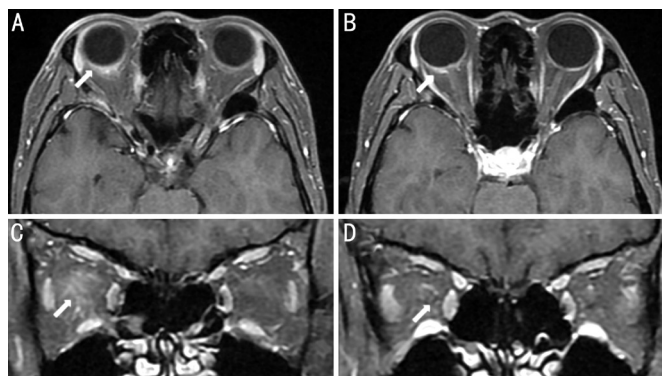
Magnetic resonance imaging scans of the orbit, with contrast infusion and fat suppression, showing an enhanced posterior sclera (A-C) and weakly enhanced optic nerve sheath (D).
